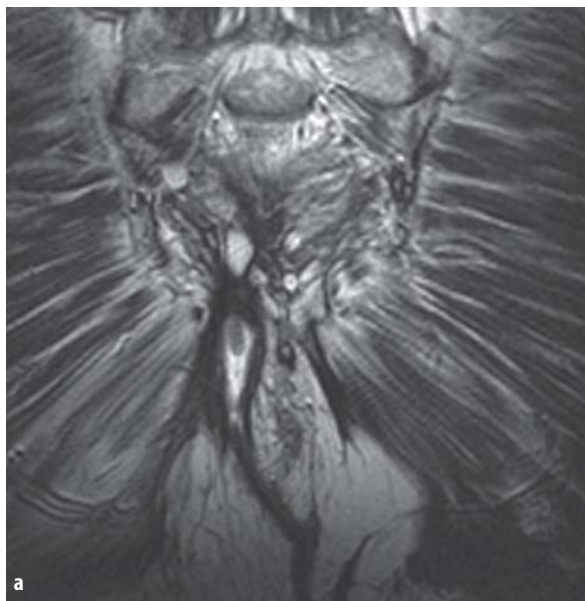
Perirectal fistulas. (a) Coronal T2-weighted rapid acquisition with relaxation enhancement (RARE) shows a trans-sphincteric fistula extending into the fatty tissue of the right ischioanal fossa and crossing the right levator ani muscle. (b) Axial T1-weighted spin-echo image shows a fistulous tract crossing the anal sphincter and extending into the adipose tissue of the right ischioanal fossa
